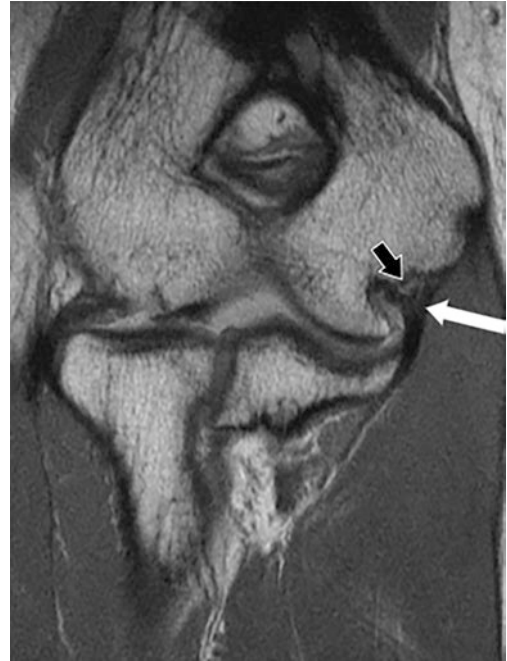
Coronal FSE MR image of a chronically remodeled UCL ligament in a pitcher (*white arrow*). The ligament is thicker than usual but is still uniformly hypointense. A small traction spur is noted arising off the slightly bulbous medial epicondyle (*black arrow*)
